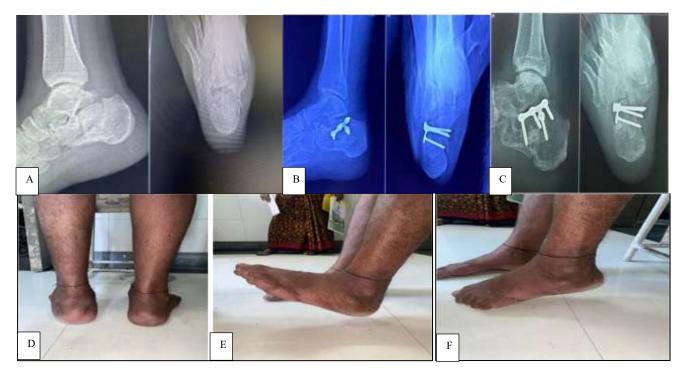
(A-F): A-pre op x-ray, B-immediate post op x-ray, C-follow up, D-heel width, E-Dorsi flexion and F-planter flexion.
